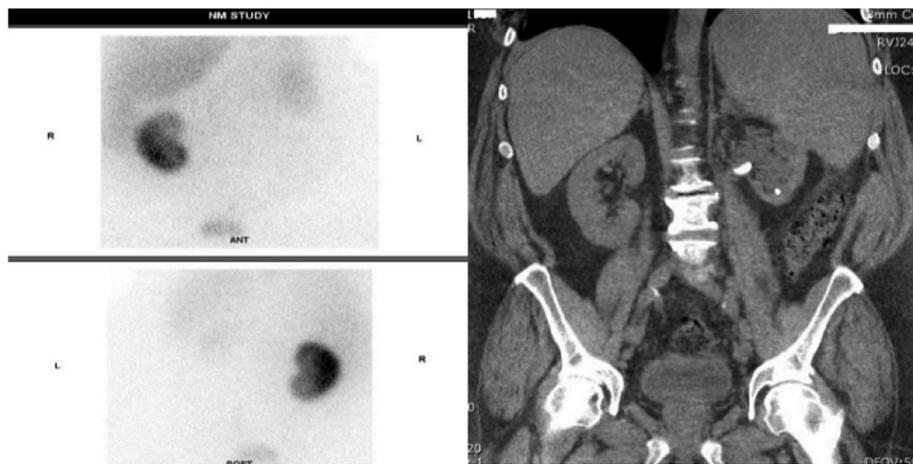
DMSA scan and CT KUB (5 months later).
